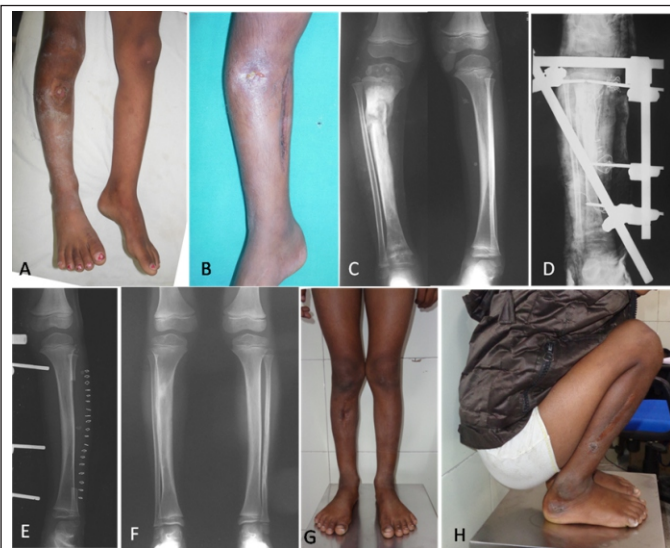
Impending fractures associated with chronic osteomyelitis managed with stabilization and bone grafting: A,B. 5 year child presented with discharging sinus in right proximal tibia. There was a large scar on the posteromedial aspect of limb representing previous operative interventions C. Radiographs revealed a large sequestrum and impending pathological fracture of proximal tibia D. Management using debridement, stabilization with external fixator and bone graft E. Fibular donor site post resection E. Follow up 3 years: Healing of the lesion and incorporation of graft. The fibular donor site has also regenerated F,G. Restoration of normal alignment and knee function.
